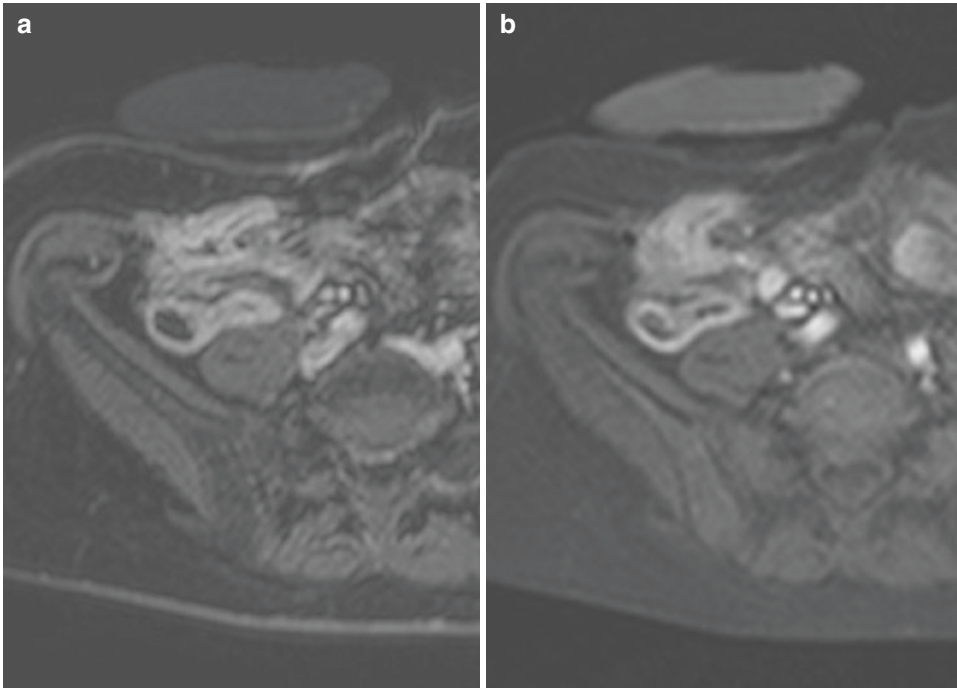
Comparison of 2D and 3D GE T1-weighted sequences in a patient with ileo-colectomy and right ileo-cutaneous stoma. Axial 2D GE T1-weighted image (a), and axial 3D GE T1-weighted image (b) with fat suppression
